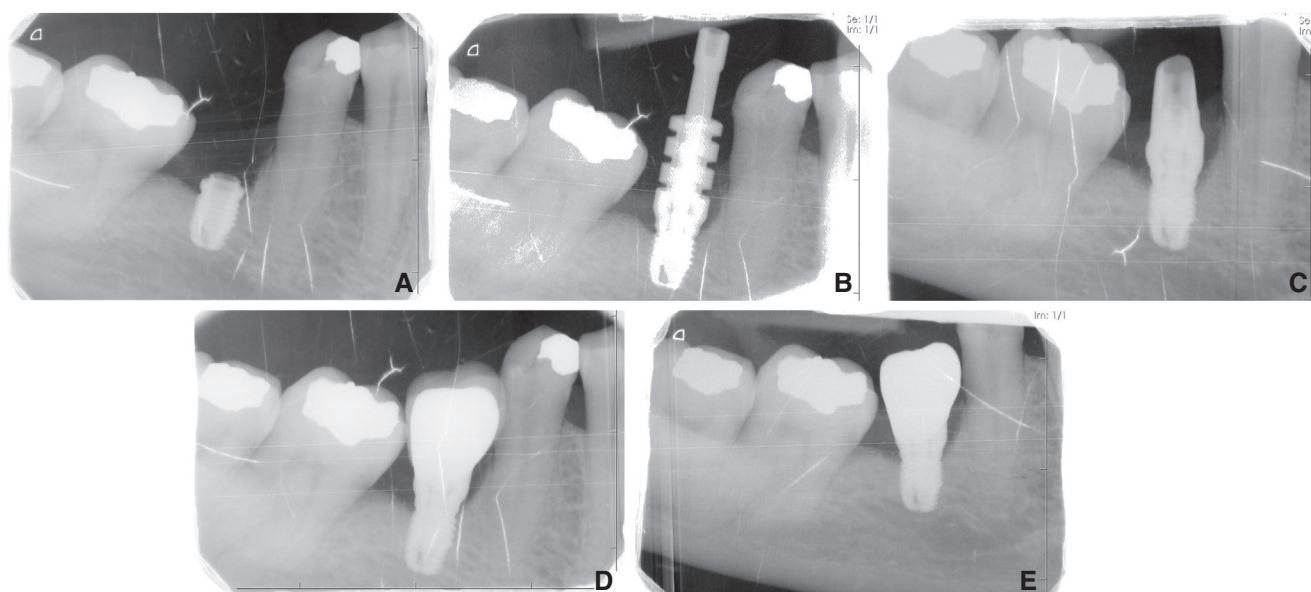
Radiographic images of representative short external connection implant. A, After implant placement. B, 3 months after implant placement. C, 6 months after implant placement. D, 12 months after implant placement. E, 24 months after implant placement.
